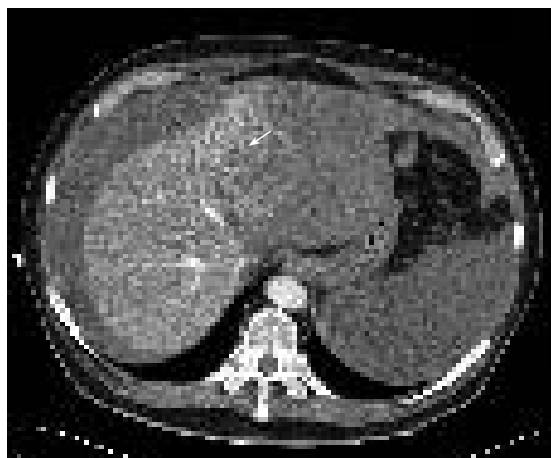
CT scan before embolization.
